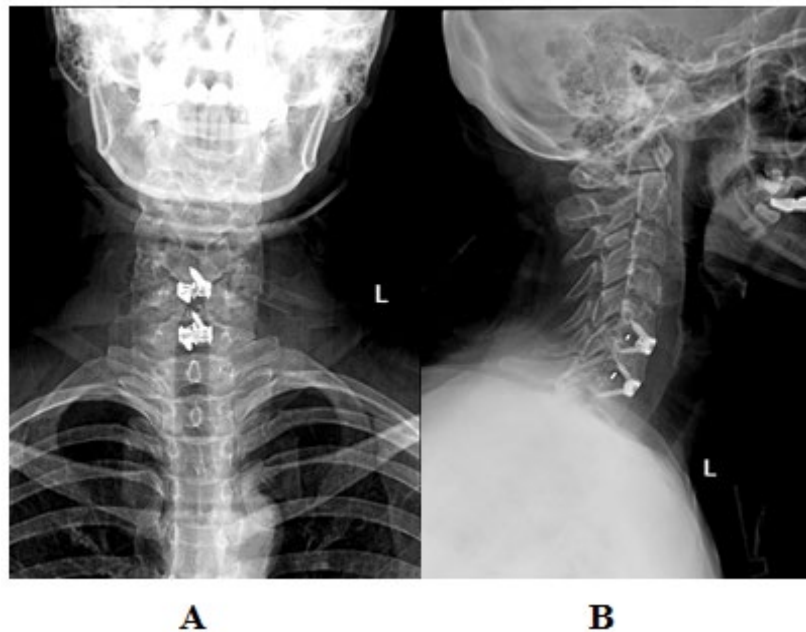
Immediate postoperative radiographs in AP and Lateral view in figures A and B respectively
